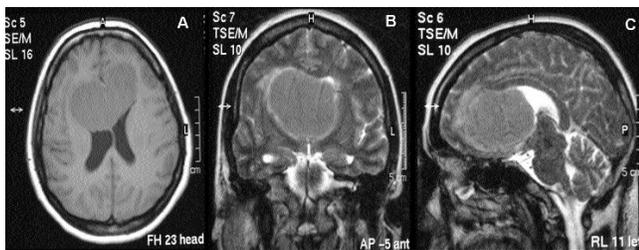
MRI of the brain tumour including (A) axial, (B) coronal, and (C) sagittal views; there is a 10×5-cm mass (white arrows), localised at the anterior cranial fossa in the midline, in front of the lateral ventricles with compression of the third ventricle and minimal oedema.
